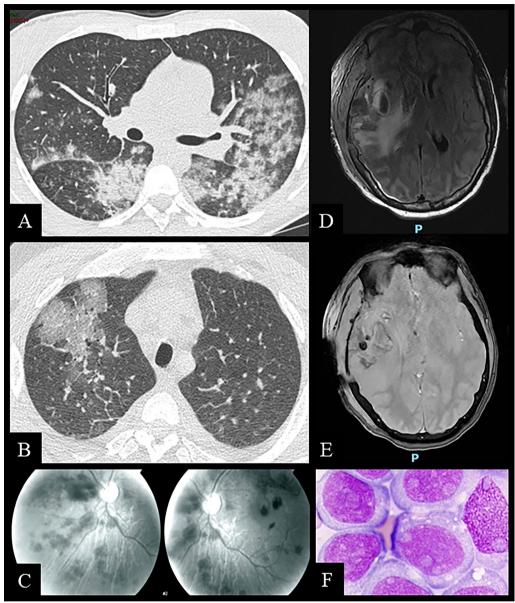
Inaugural complications of acute myeloid leukemia requiring emergency chemotherapy. A Pulmonary leukostasis, with bilateral alveolar and interstitial opacities, related to hyperleukocytic $(230 \times 10^9/L)$ acute monocytic leukemia (ex FAB-M5) at the time of diagnosis. B Pulmonary leukostasis, with ground-glass opacity in the right upper lobe, secondary to hyperleukocytic $(200 \times 10^9/L)$ acute myelomonocytic leukemia (ex FAB-M4). C Fundus image with fluorescein angiography revealing hyperviscosity-related retinopathy with disseminated retinal hemorrhages and vascular dilation. D, E T2*-weighted and T2-flair MRI sequences revealing inaugural left fronto-temporal hemorrhage and cerebral edema linked to hyperleukocytic $(330 \times 10^9/L)$ acute monocytic leukemia (ex FAB-M5). F Acute monocytic leukemia (ex FAB-M5): peripheral blood smear with numerous promonocytes that have folded and convoluted nuclei and a finely granulated cytoplasm and vacuoles. *DIC* disseminated intravascular coagulation, *FAB* French–American–British classification, *MRI* magnetic resonance imaging
